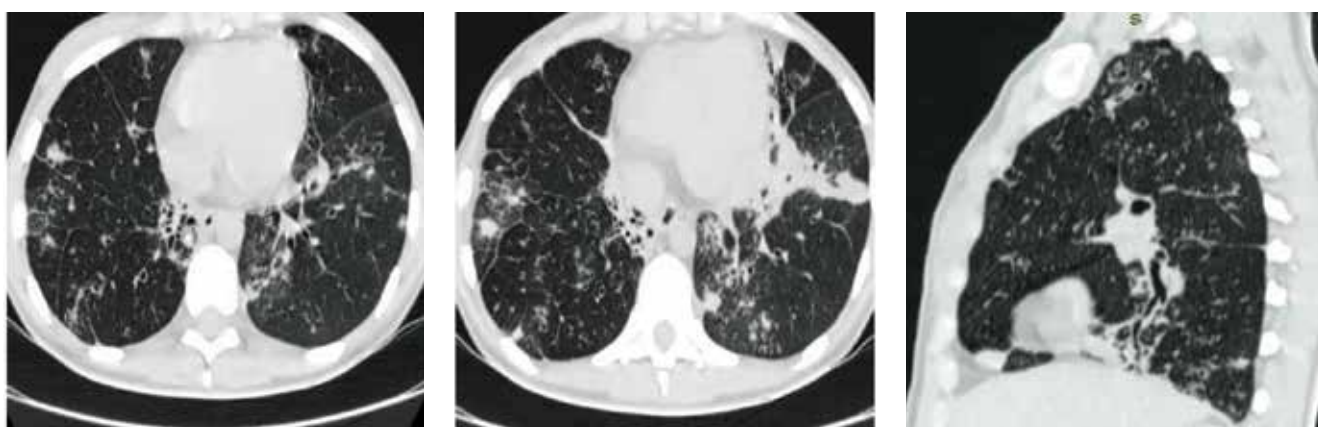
Chest CT (28.05.2021). Signs of focal dissemination with consolidation around bronchiectasis in moderate pneumofibrosis
